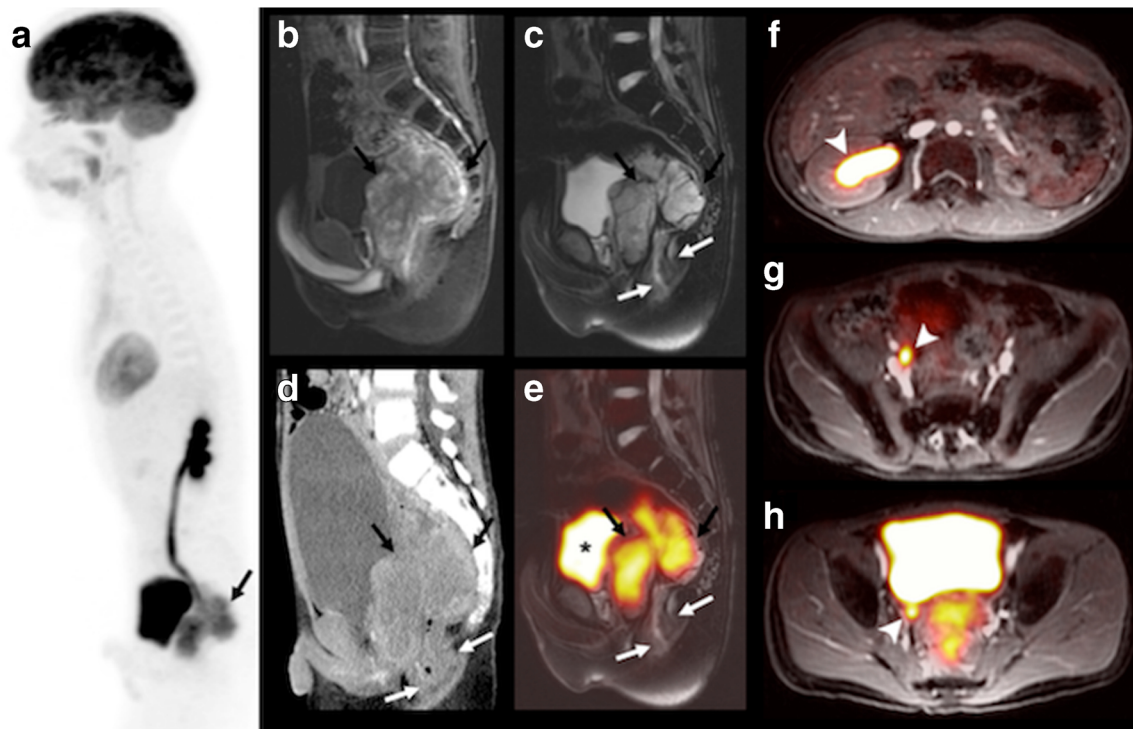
PET/MR and CT findings in an 11-year-old boy with status post-resection of a Wilms tumor of the left kidney and recurrent tumor in the pelvis. This patient with a single, mildly hydronephrotic kidney benefitted from omission of nephrotoxic contrast agent for the scan. a Sagittal maximum intensity projection [¹⁸F]FDG PET shows a hypermetabolic mass behind the bladder (*black arrow*). b Sagittal T1-weighted ferumoxytol-enhanced LAVA scan (TR/TE/Flip angle: 4/1.7/15) shows T1 enhancement of the tumor, but not the bladder. c, e T2-weighted ferumoxytol-enhanced FSE scan (TR/TE/Flip angle: 4634/69.2/142) without and with superimposed ¹⁸F-FDG PET shows better tumor delineation of retrovesical tumor (*black arrows*) from the adjacent rectum (*white arrows*) and bladder (*asterisk*), compared to d sagittal contrast-enhanced CT. f-h Axial T1-weighted ferumoxytol-enhanced LAVA scans with superimposed [¹⁸F]FDG PET (TR/TE/flip angle: 4.2/1.7/15) nicely shows enhancing vessels and a dilated [¹⁸F]FDG filled ureter and renal pelvis (*white arrowhead*) due to tumor obstruction.
